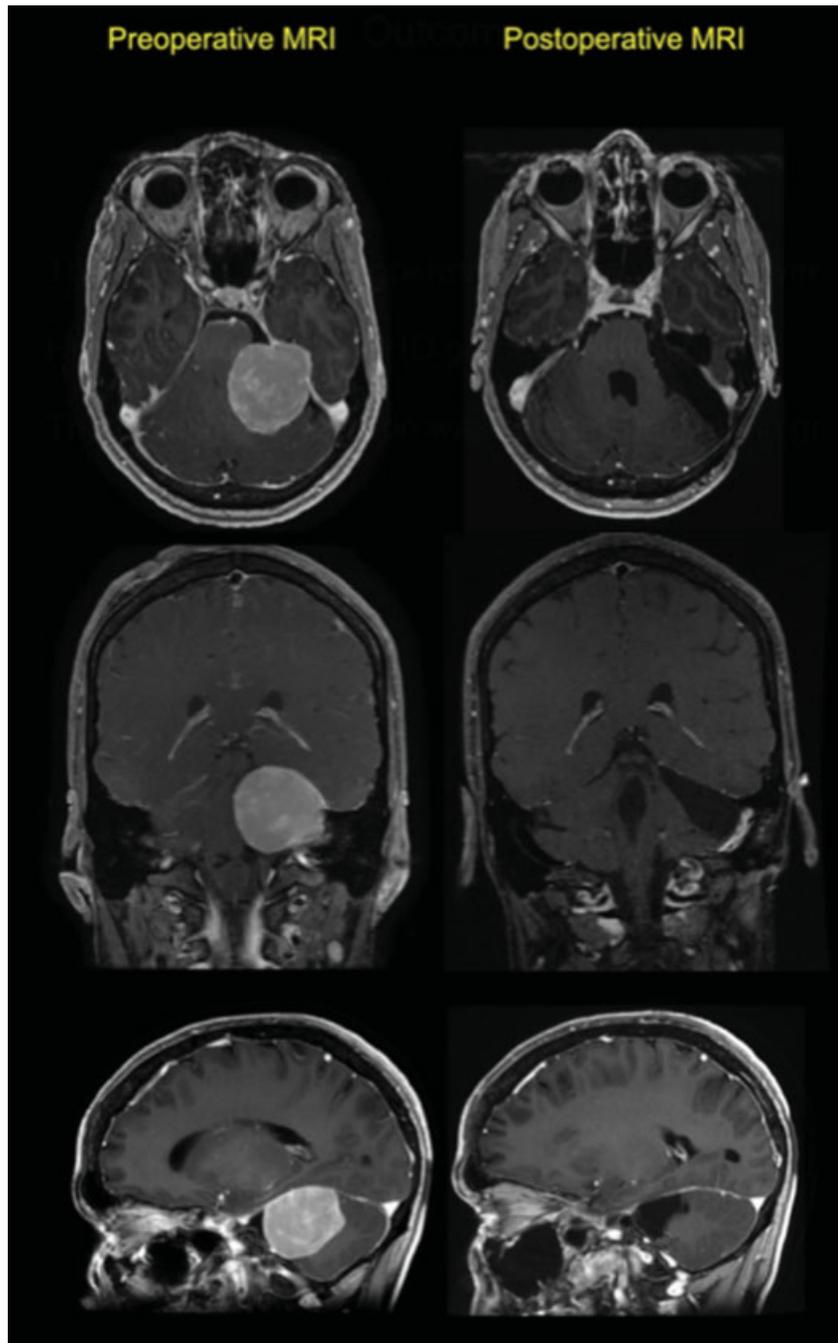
Pre and postoperative magnetic resonance imaging.
